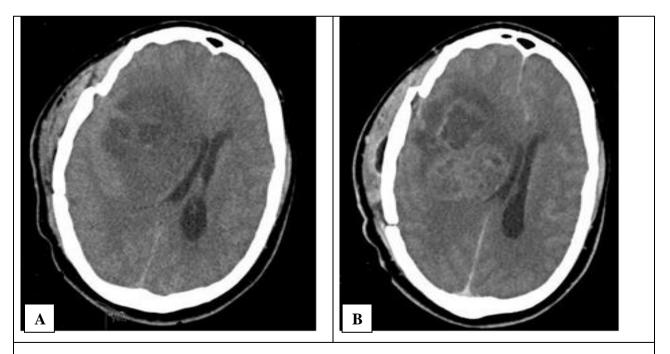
Axial head computed tomography scans (A. native, B. after contrast administration) performed on patient's second admission (at two weeks after first tumor resection) identified temporal scalp swelling, temporal craniotomy and increased lesion size with compression and dislocation of medial cerebral structures to the left.
